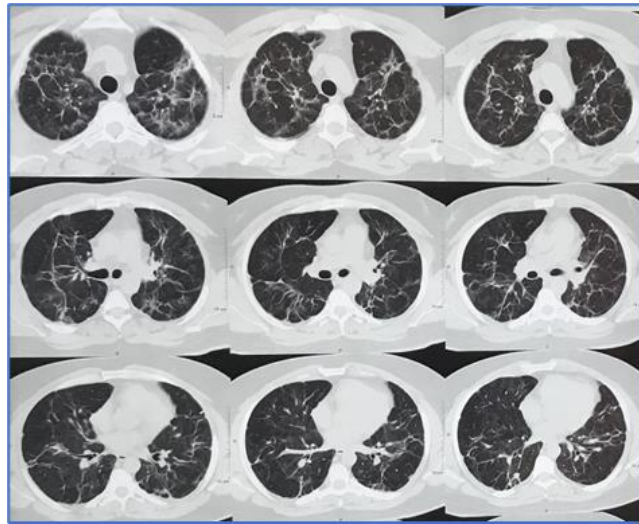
HRCT thorax showing interstitial opacities classically described as linear and parenchymal bands without loss of lung volume in bilateral upper lobes
